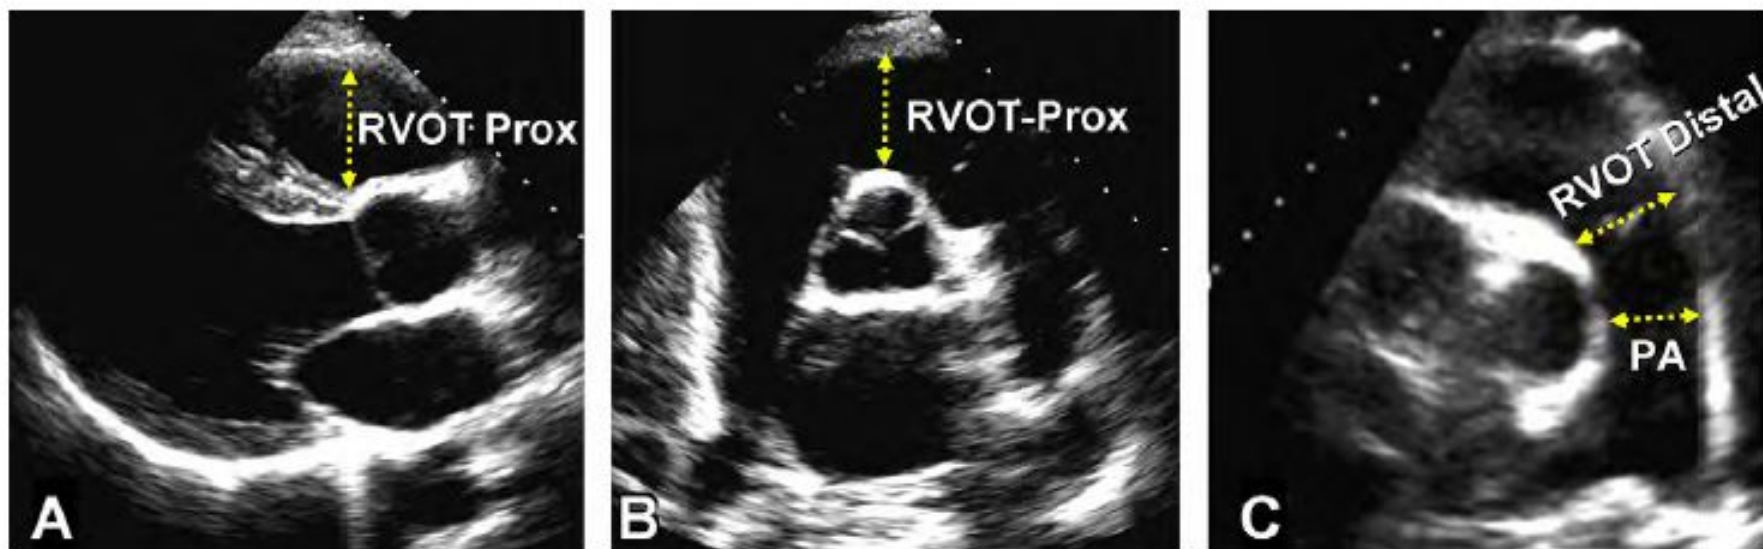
Measurement of right ventricular outflow tract (RVOT) dimensions at the proximal or subvalvular level (RVOT-Prox) and at the distal or pulmonic valve (RVOT-Distal) in the (A) parasternal long-axis RVOT anterior portion view, (B) basal parasternal short-axis view, and (C) parasternal short-axis of pulmonary bifurcation view. *PA*, Pulmonary artery dimension between valve and the bifurcation point.
